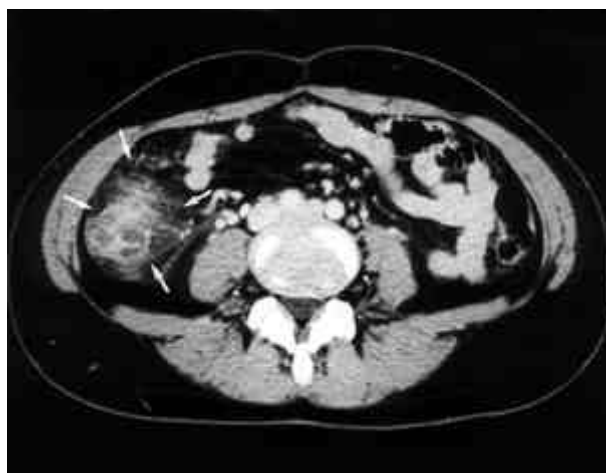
Colonic diverticulitis. Contrast-enhanced CT shows thickening of the colonic wall with mural edema. Also noted is diffuse pericolic infiltrates (arrows).
